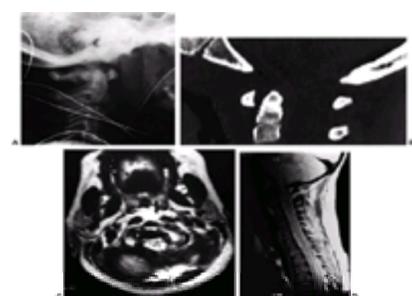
This 5-year, 6-month-old girl was hit by a van from behind, and presented with bilateral palsies of cranial nerve VI. A: The lateral radiograph of the upper cervical spine demonstrates a rotational malalignment. The basion hemishadows fail to overlap, whereas the C1 arches nearly superimpose on each other, raising the concern for atlantooccipital dislocation. B: A computed tomography scan with sagittal reconstruction demonstrates elevation of the periosteum at the caudal level of the clivus level (arrows) and hemorrhage (arrowheads). C: An axial image from the magnetic resonance imaging scan demonstrates abnormal fluid accumulation immediately anterior to the atlantooccipital junction (arrow). D: The magnetic resonance imaging scan sagittal view demonstrates subarachnoid space narrowing at the level of the foramen magnum and the atlantooccipital joint.
